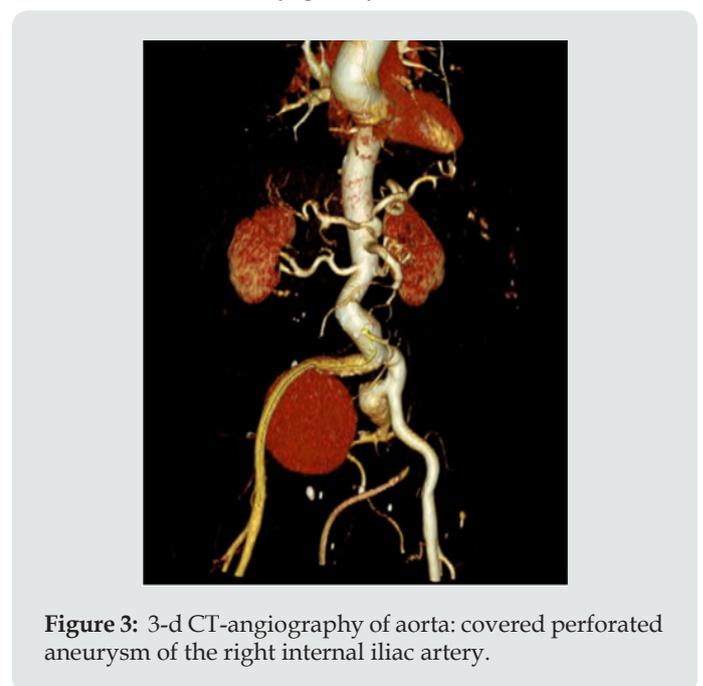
3-d CT-angiography of aorta: covered perforated aneurysm of the right internal iliac artery.
